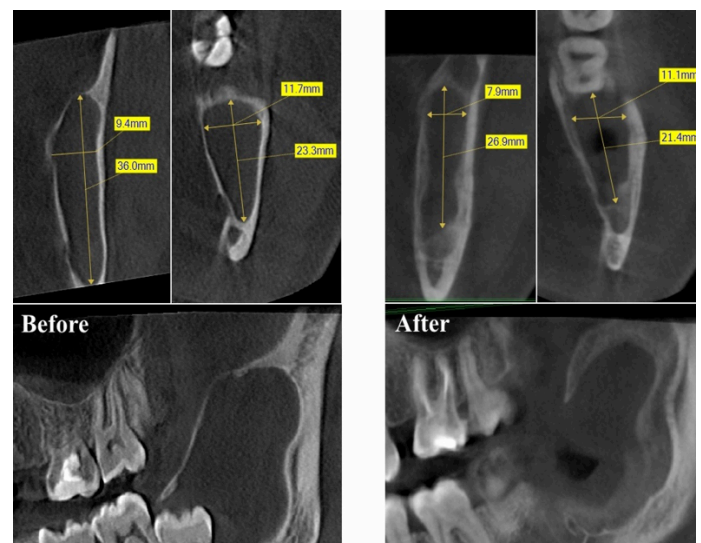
Showing the reduction of lesion dimensions four months after marsupialization followed by decompression. Preoperative and postoperative CBCT scans.
